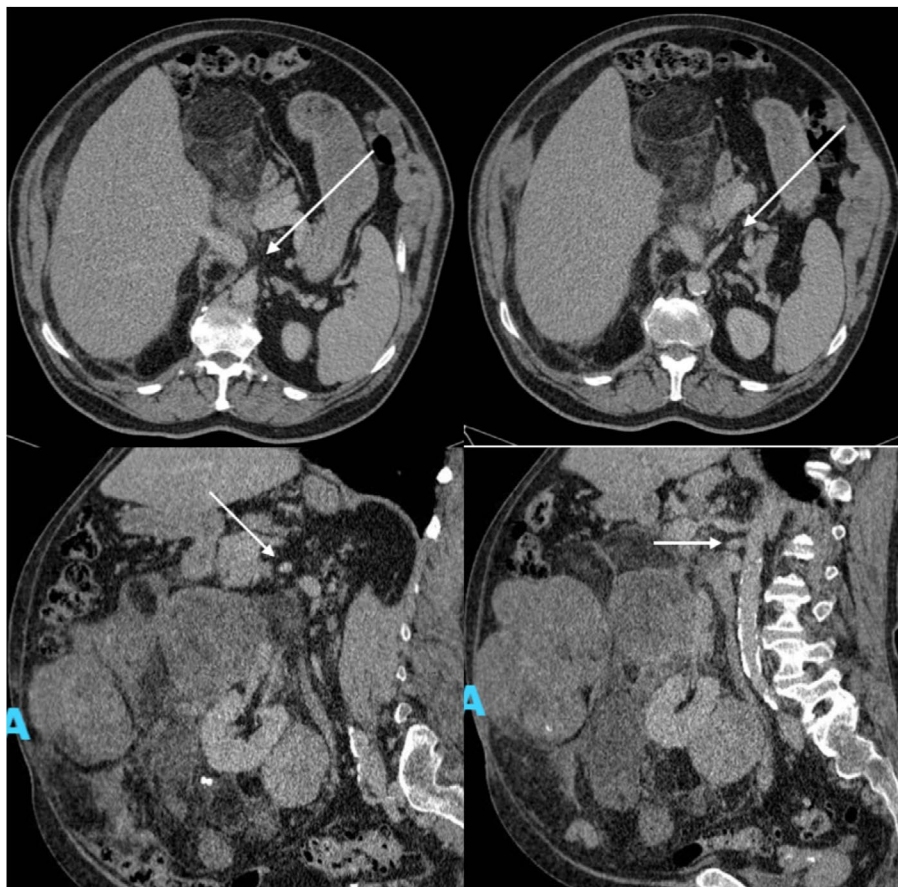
Computer tomography (CT) axial and sagittal planar imaging demonstrating an unresectable RPS secondary to involvement of the SMA (arrow).
